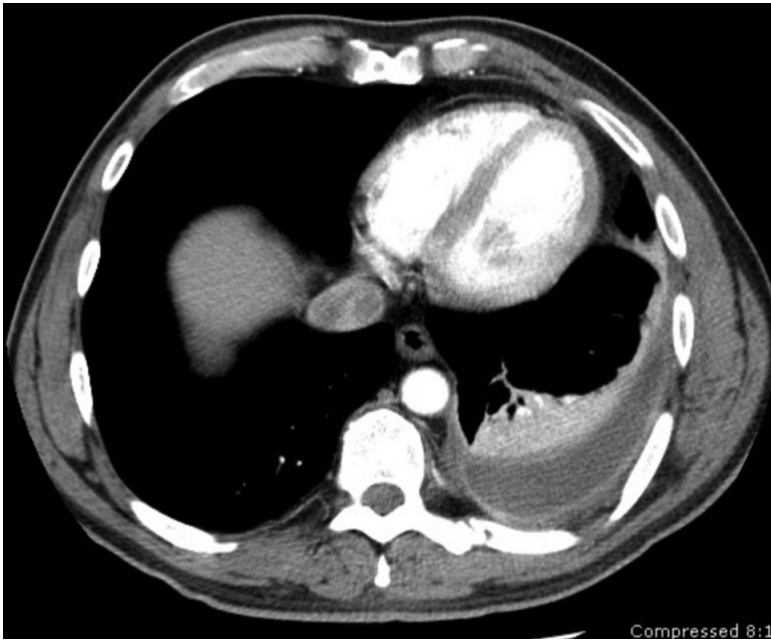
Computed tomography scan shows a left effusion with pleural thickening.
